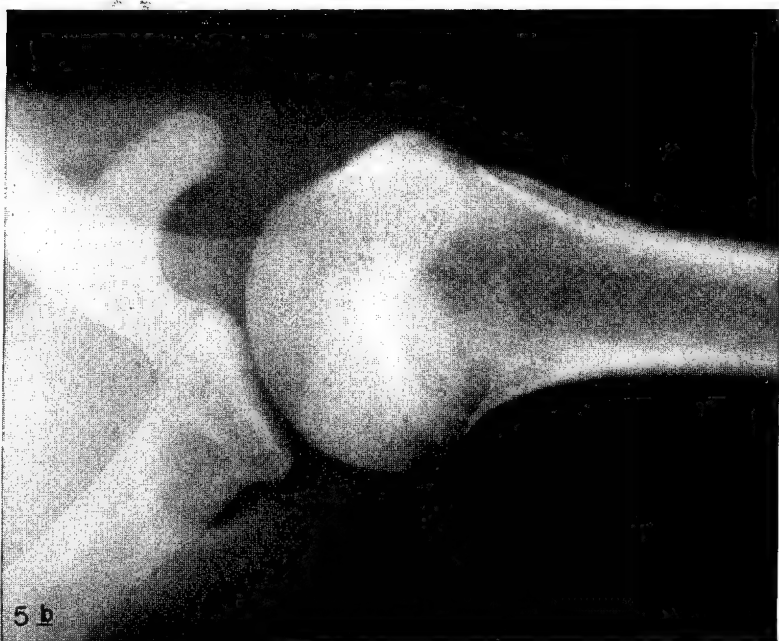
(5a) Anteroposterior roentgenogram of a control patient showing flattening of the posterolateral surface of the humeral head. (5b) Lateral view of a control patient showing similar flattening.
